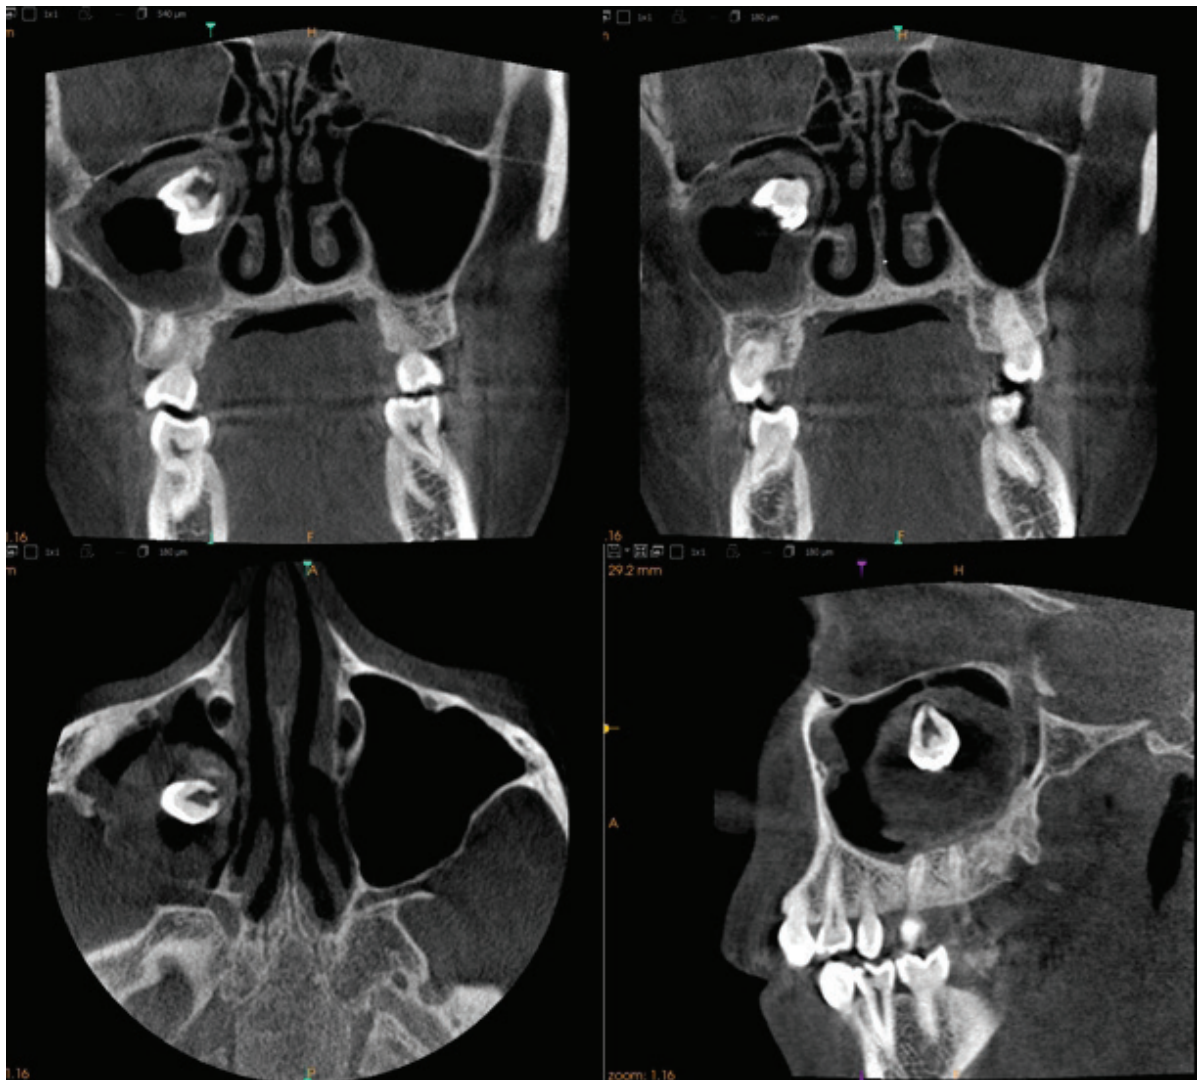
CBCT revealed an ectopic molar in the upper medial part of the maxillary sinus with cystic changes
